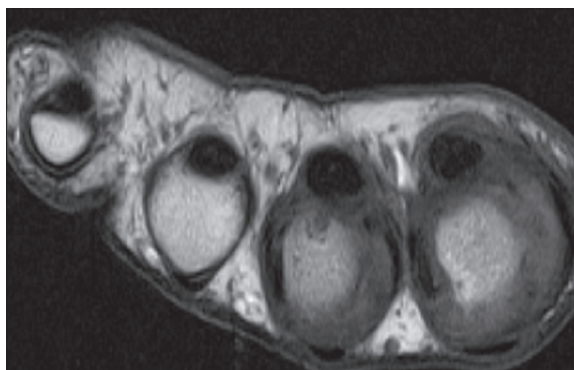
MR FSE T1-weighted image of metacarpophalangeal joints in the same patient. Synovium hypertrophy involving the II and III metacarpophalangeal joint and tendinous sheaths of flexor digitorum. A small erosion can be seen in the III metacarpal bone.
